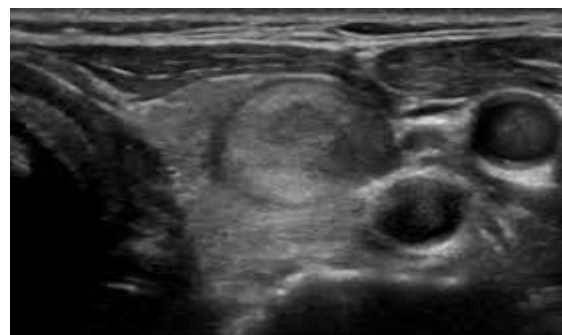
Ultrasound features shown in the figure of hypoechoic thyroid nodules proved as papillary carcinoma by cytology
